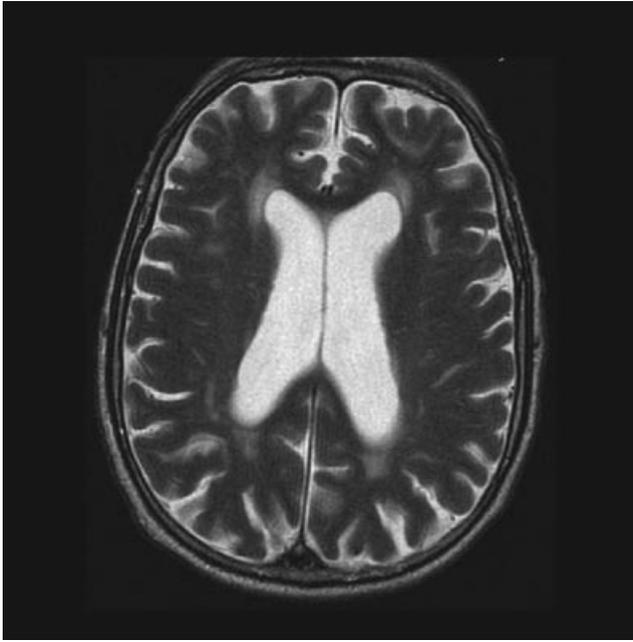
T2 sequence MRI showing white matter changes that may be seen in NPH.
